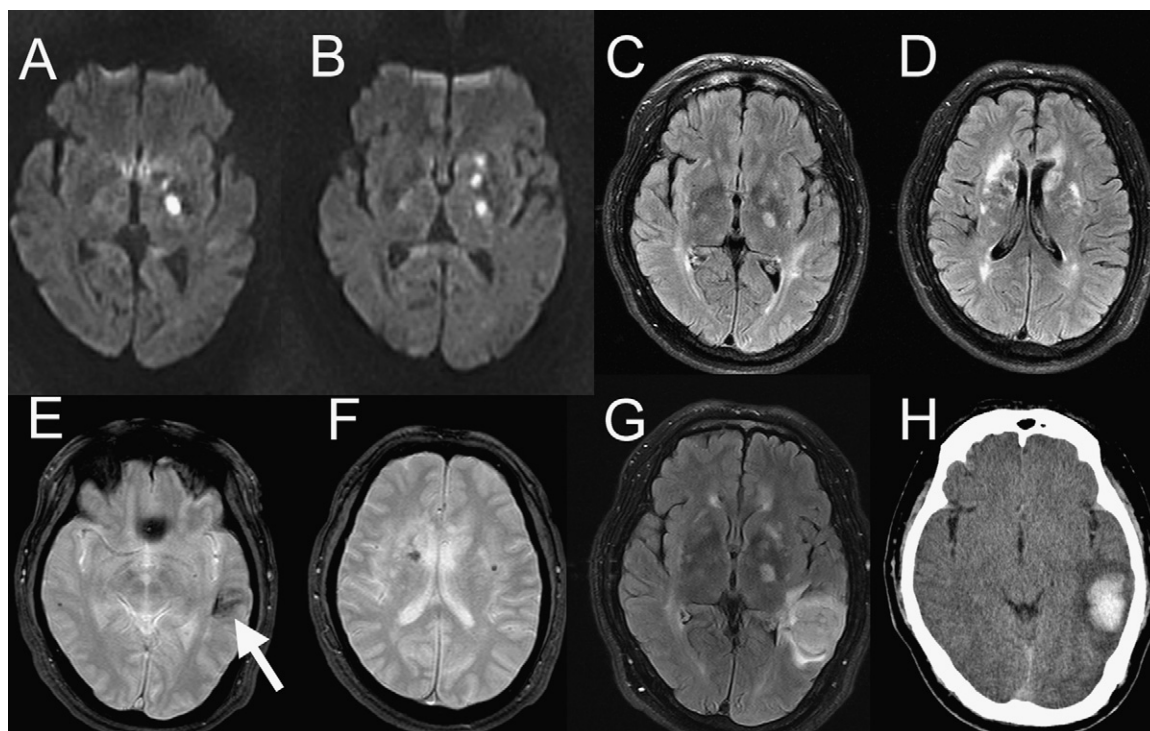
Initial diffusion-weighted images (A and B) show multiple small lesions on the left internal capsule and basal ganglia. There are multiple white matter high signal intensity lesions on initial FLAIR images (C and D). Gradient echo images (E and F) demonstrate several microbleeds and an old hemorrhage on the left temporal lobe (arrow). FLAIR (G) image at second admission shows newly developed hyperacute hematoma on the left temporal lobe. Follow up CT (H) done five days later shows no significant change of the size of hematoma.
